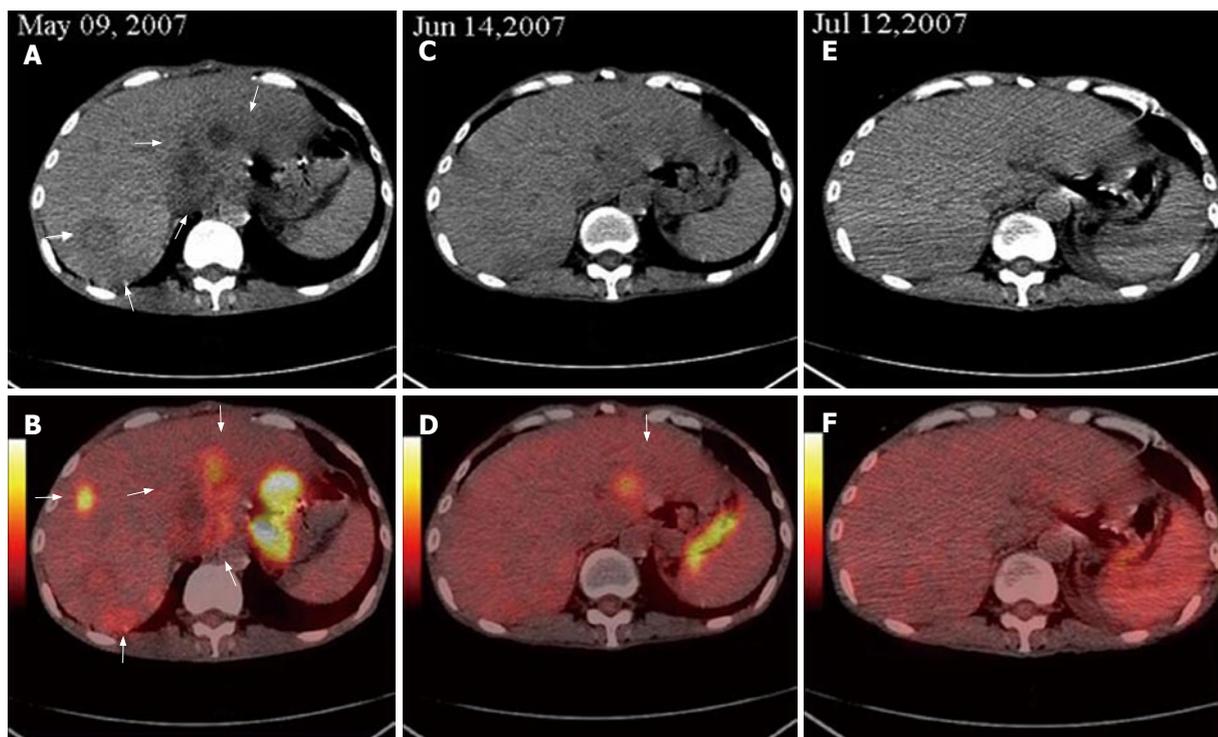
Base line FDG PET/CT detecting a highly metabolic metastasis in liver (white arrows, A and B), second FDG PET/CT demonstrating the decreased number and metabolism level of liver metastases and one highly metabolic metastasis in the left lobe of liver (white arrows, C and D), third FDG PET/CT displaying no lesion at the same position (E and F).
